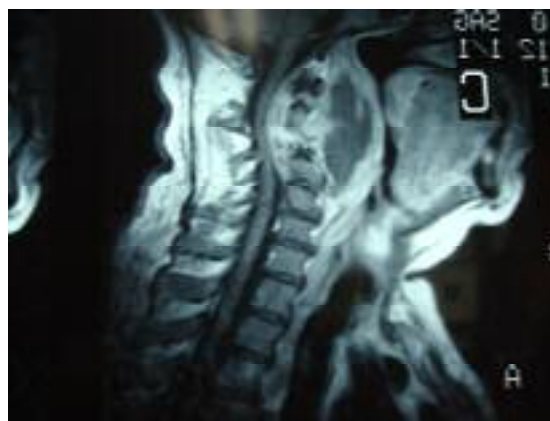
Sagittal T2-weighted MRI demonstrating a collection consistent with abscess formation.
